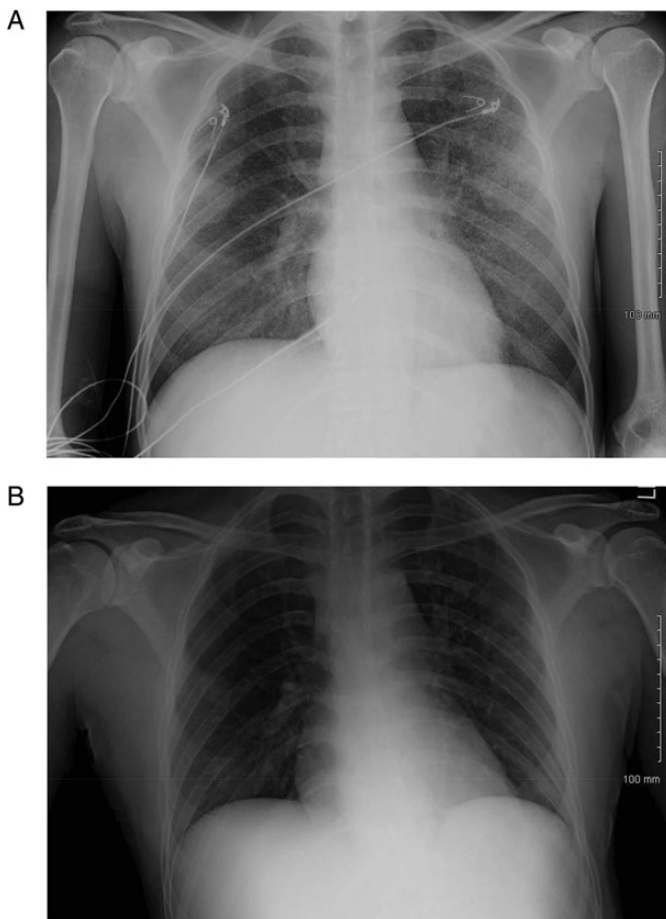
(A) Chest X-ray with a miliary pattern and a 'tree-in-bud' sign across right and left lung fields. (B) Normal chest X-ray 3 months prior to presentation.
